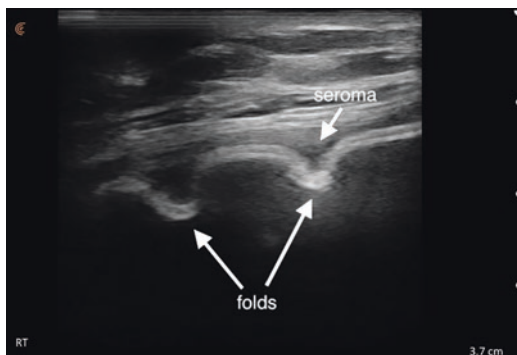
Grayscale ultrasound image of a breast implant exhibiting capsular contracture. Multiple folds and a small amount of seroma are seen
